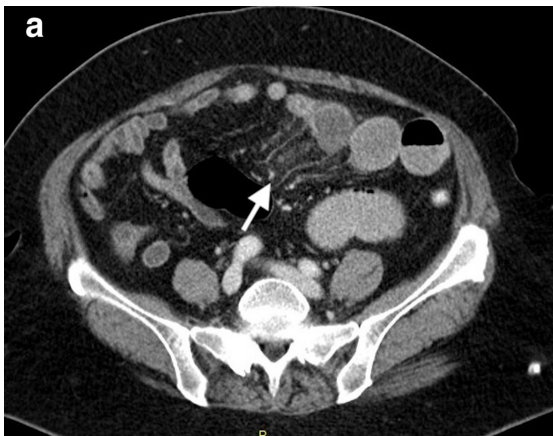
Axial (a) and coronal (b) contrast-enhanced computed tomography images of a 70-year-old female patient with coronavirus disease-2019 revealing perivascular infiltration, mesenteric stranding (arrows), and bowel dilatation, which indicates bowel ischemia. The patient underwent segmental bowel resection surgery because of the progressive deterioration in her clinical status.
